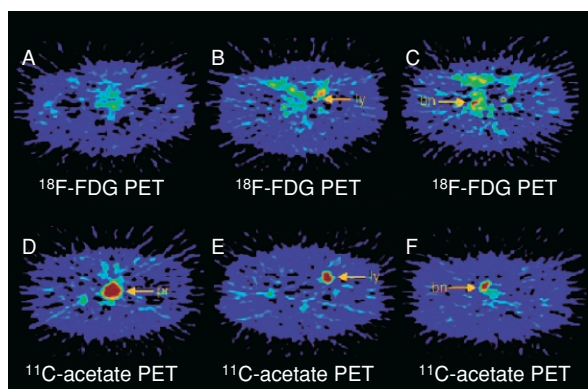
PET images of prostate, lymph node, and bone metastases obtained using ¹⁸F-FDG (upper row) and ¹¹C-acetate (bottom row) from 73-y-old man with poorly differentiated (Gleason score 7) adenocarcinoma of prostate. bn=bone; ly=lymph node; pr=prostate. (Data from reference¹⁵⁾).
